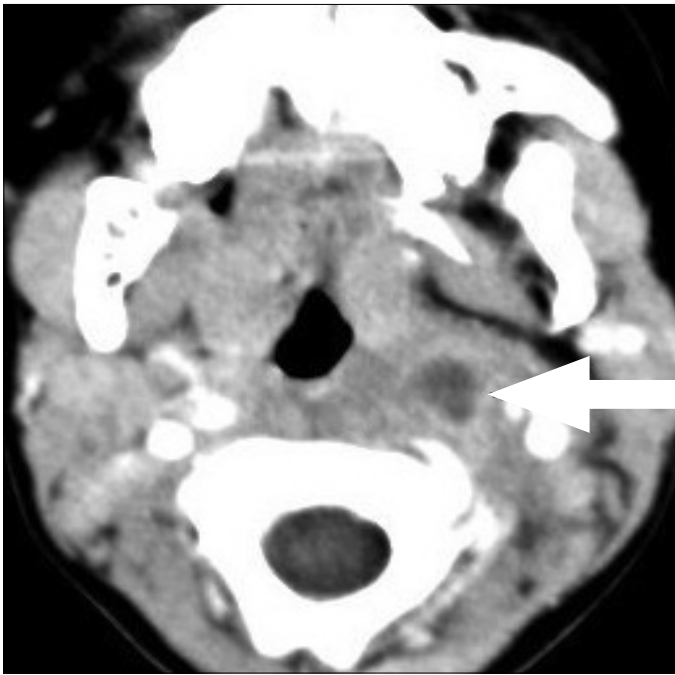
In the contrast-enhanced computerized neck MRI examination, there is an inflammation extending from the left parapharyngeal localization to the retropharyngeal zone, the image compatible with central cut hypodense abscess showing peripheral contrast involvement on the left parapharyngeal zone (Patient number 17)
